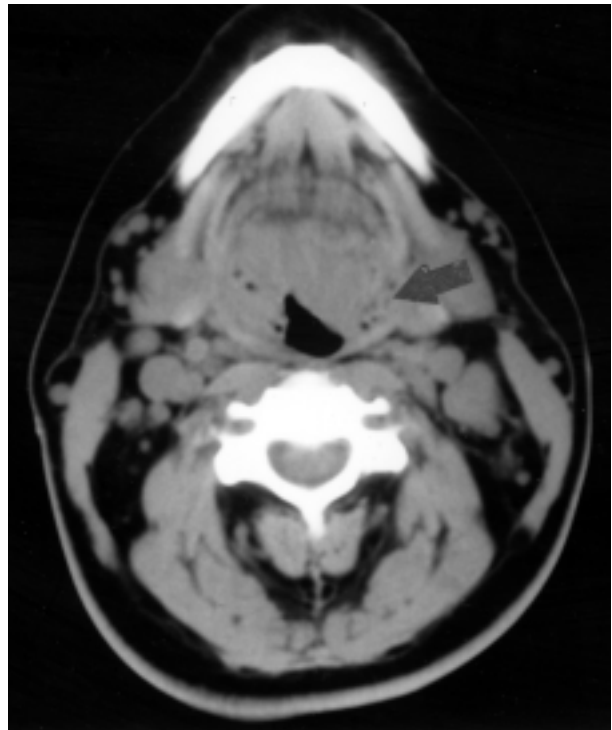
Computed tomography scan of patient 2, showing supraglottitis and soft-tissue gas (arrow).
